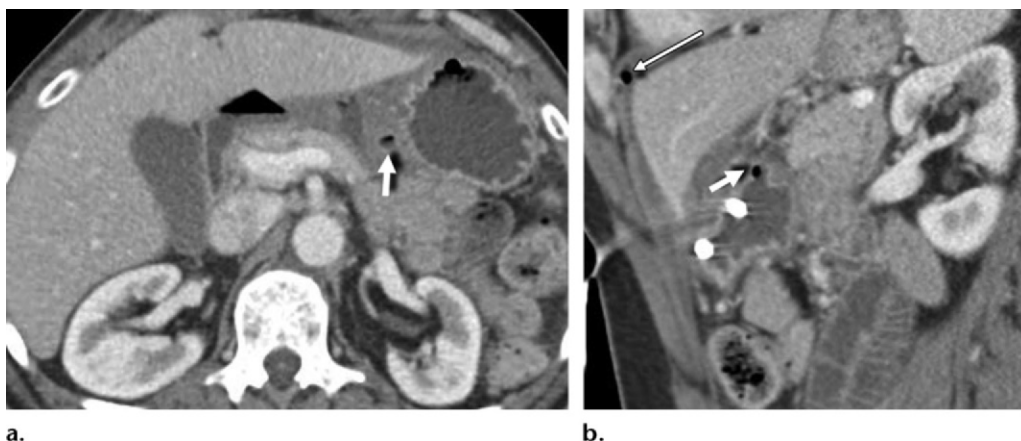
Perforated peptic ulcer in a patient who presented to the emergency department with acute onset of severe left upper quadrant abdominal pain. (a) Axial CT image demonstrates a transmurular ulcer crater (arrow) with an adjacent mound of edema in the superior gastric antral wall. (b) Sagittal CT image shows the ulcer (thick arrow), as well as foci of free intraperitoneal air (thin arrow) adjacent to the liver, consistent with perforation.
